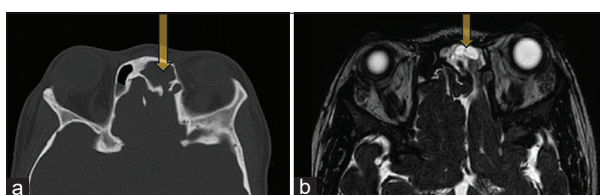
(a) Axial high-resolution computed tomography shows defect in the left cribriform plate and (b) heavily T2W 3D DRIVE sequence shows herniation of the dysplastic basifrontal lobe through the defect
